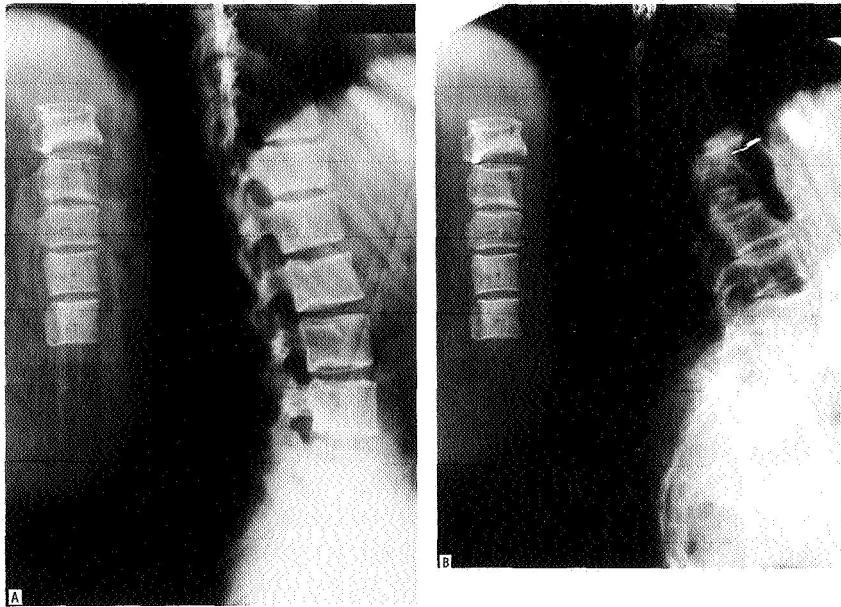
Roentgenographs of the spondylometer and lumbar spine of (a) 50-year-old nonosteoporotic woman and (b) a 70-year-old woman with severe osteoporosis.
